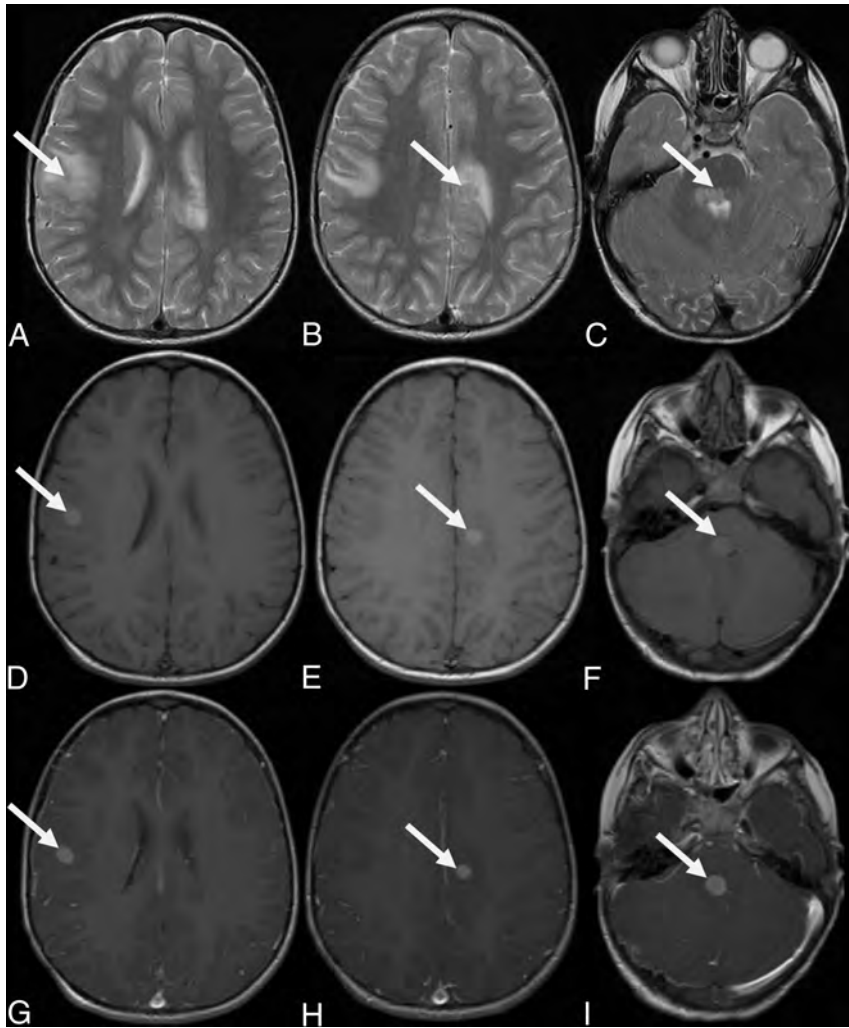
Brain MR images of a 3-year-old boy with pathology-proven multifocal JXG and new-onset strabismus. Axial T2-weighted (A–C), axial T1-weighted (D–F), and axial T1+CE-weighted (G–I) MR imaging sequences show exemplary 3 round-to-oval lesions located in the right (arrows in A, D, and G) and left paracentral (arrows in B, E, and H) regions and the pons (arrows in C, F, and I), respectively. Compared with cortical GM, the lesions are T2-iso- to hyperintense (A–C) and T1-hyperintense (D–F) and show homogeneous contrast enhancement (G–I) and mild perilesional edema.
